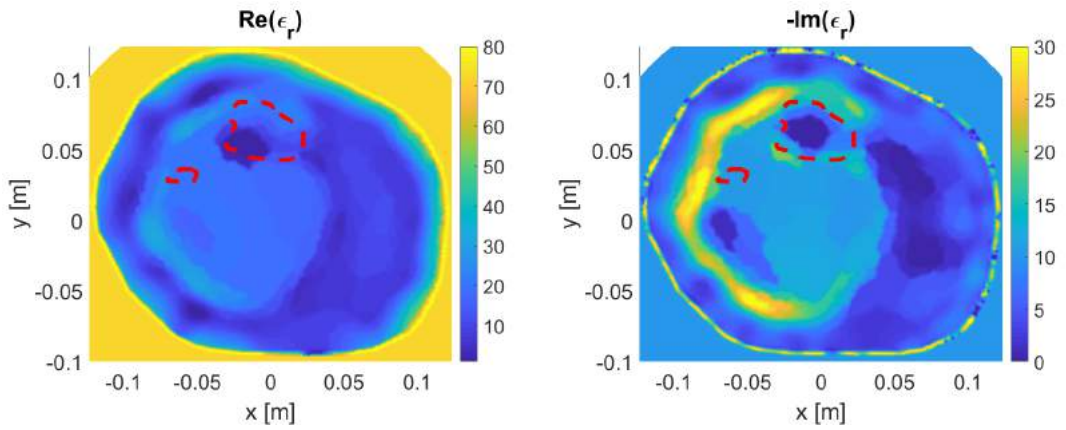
Inversion results for the real-part based clustering model using the ultrasound gel with mid-value inhomogeneous scenario.
